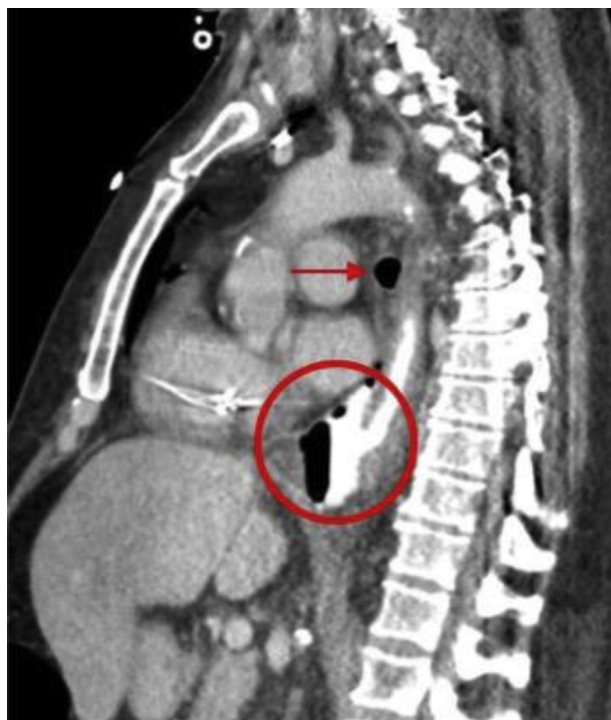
Sagittal computed tomography (CT) views of large perforation involving the distal portion of the esophagus with extraluminal oral contrast material (circle). Pneumomediastinum is also present (arrow).
